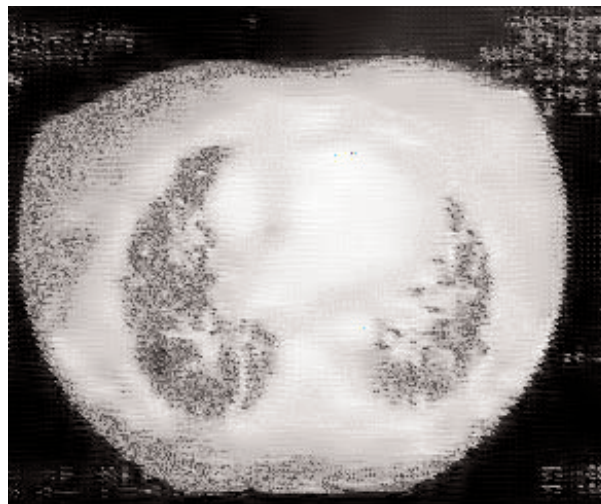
Computed tomography with massive bilateral interstitial infiltrates, thickened interlobular septal lines and massive alveolar occupation in both lung.
